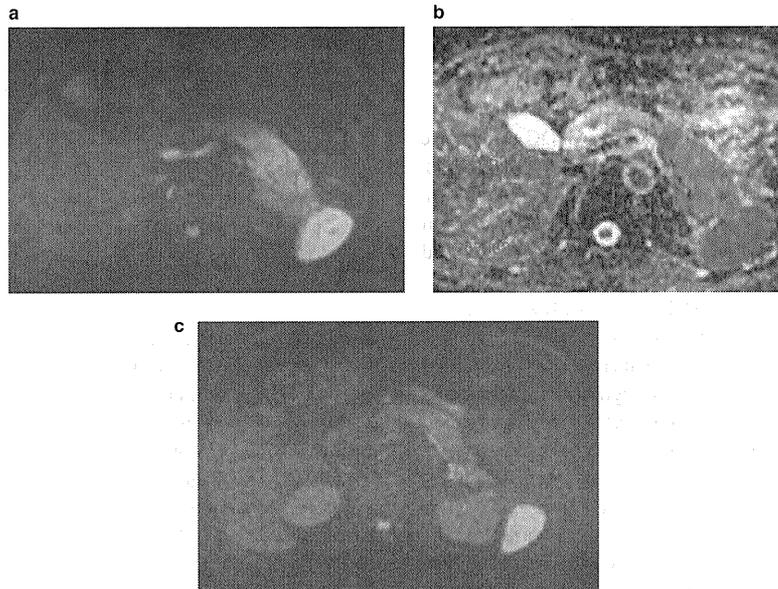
Segmental-type autoimmune pancreatitis. (a) Diffusion-weighted magnetic resonance imaging showing a longitudinal high-intensity area (*b*=800 mm²/s). (b) ADC map in the same patient. (c) Diffusion-weighted magnetic resonance imaging showing a markedly decreased high-intensity area 2 months after starting steroid therapy (*b*=800 mm²/s). ADC, apparent diffusion coefficient.
